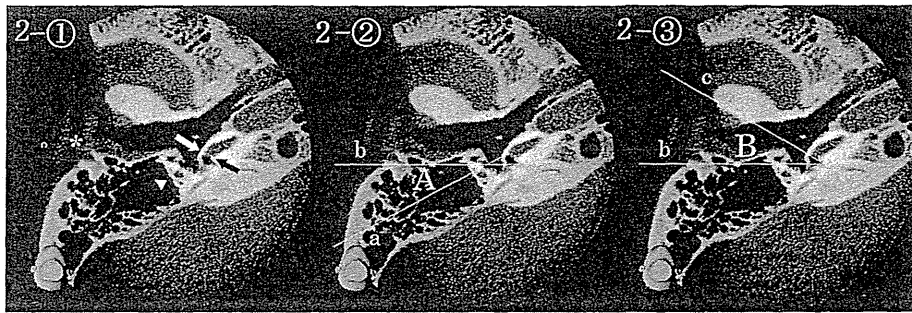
右側頭骨軸位CBCT画像における蝸牛窓解剖の計測法
